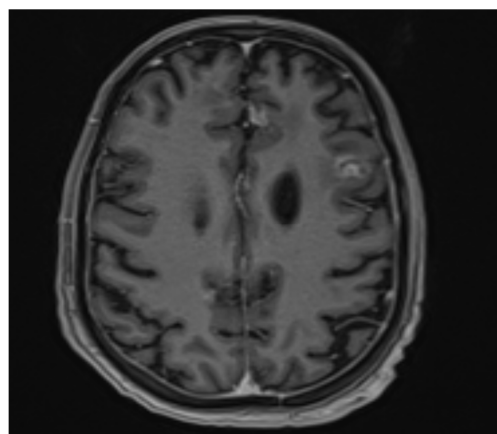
Image of cerebral tuberculosis MRI.
